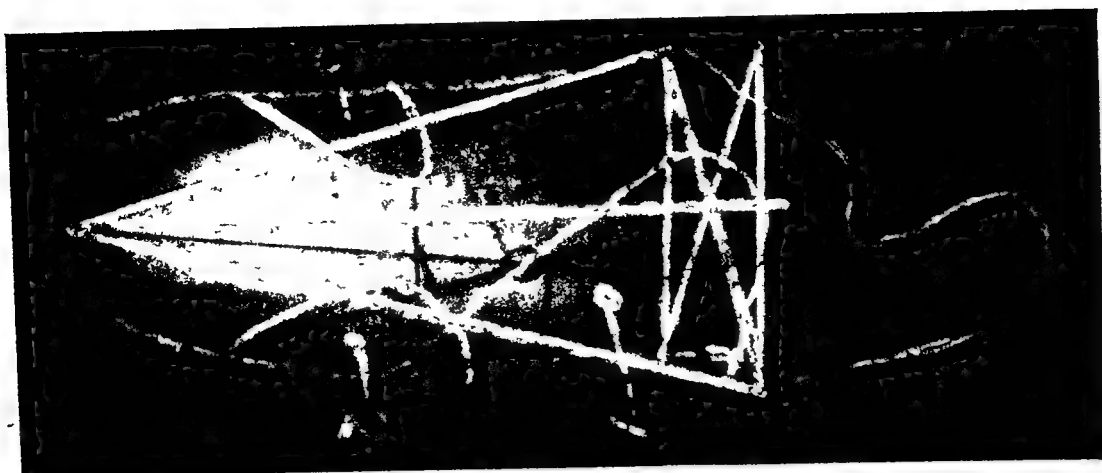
RADIOGRAPHIC CHART FOR TRI-WEDGE BALANCED APPLIANCE (Moss principle).
